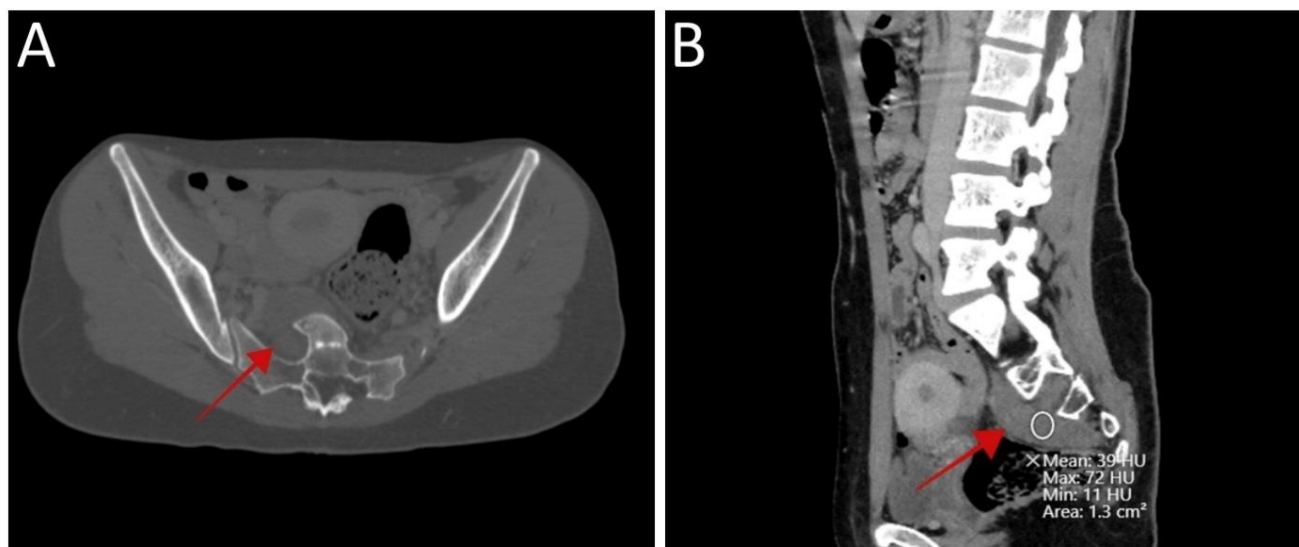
Pre-operative CT scan with contrast displaying well-circumscribed lesion in the presacral area with a rim of peripheral enhancement causing widening of the right middle neural sacral foramina and remodeling of the adjacent structures with no calcifications (red arrow) and the mean Hounsfield unit is 39: (A) axial view and (B) sagittal view. [CT = computed tomography, HU = Hounsfield unit]
